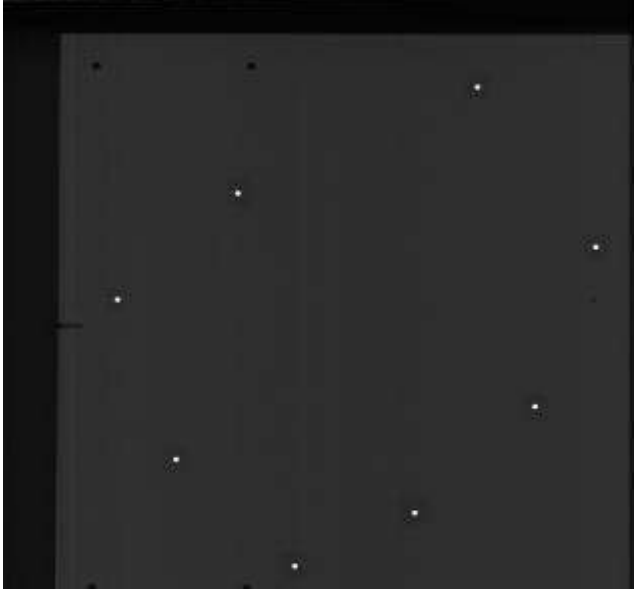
X-ray of calibration tool with frontal view (left) and oblique view (right).
